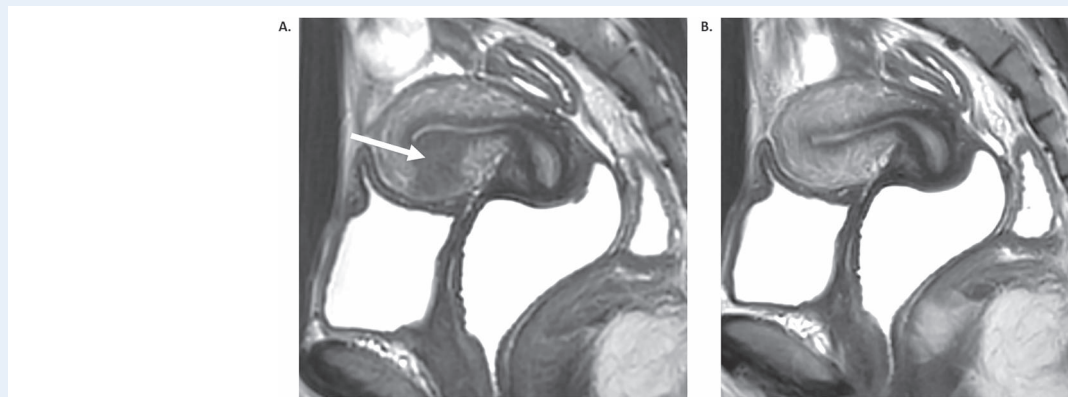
MRI sagittal T2-weighted images of a transient uterine contraction. The contraction mimics (A) a focal thickening of the JZ, that (B) disappears in the sequence acquired 7 min later.
